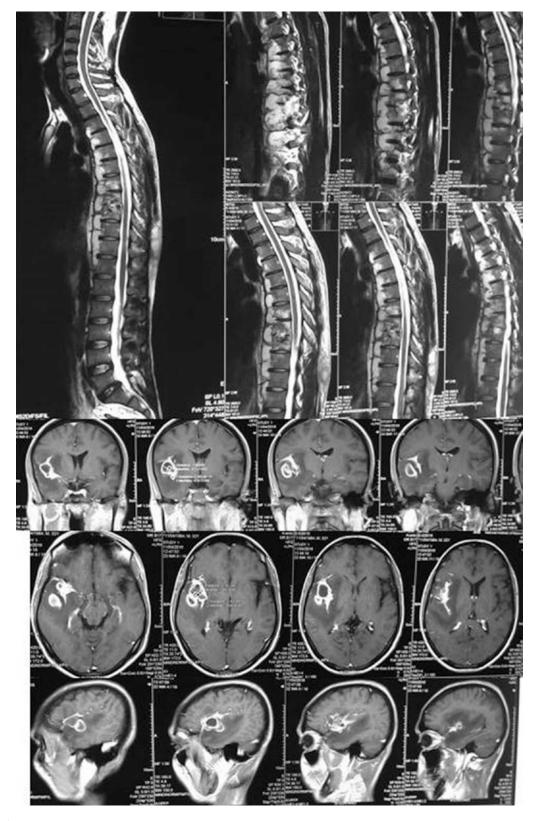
MRI of the brain and spine demonstrates simultaneous TB lesions located right sylvian fissure and Th7–Th9 vertebrae in same patient (Courtesy of FH Chowdhury)
